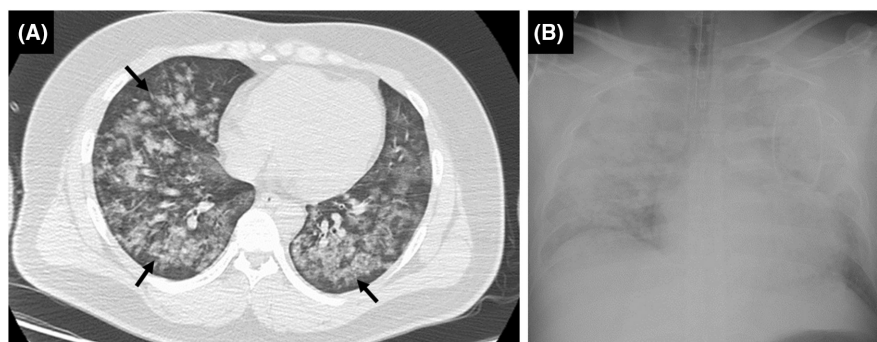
Chest computed tomography image (A) and chest X-rays (B) before the introduction of extracorporeal membrane oxygenation. (A) Bilateral ground-glass opacities (arrow) are shown, indicating pulmonary edema. (B) The diffuse infiltration throughout all lung fields is shown.
